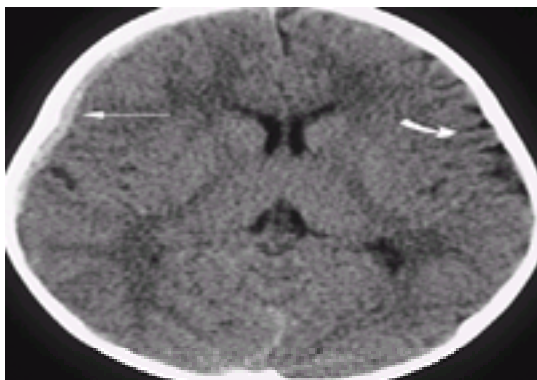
Brain swelling. This 1-year-old boy fell from a second-story window. The neurologic examination was normal. A head computed tomography (CT) scan shows a small, right-sided subdural hematoma in the temporal region. Note also the effacement of the sulci on the right (*straight arrow*), which can be compared with the normal sulci on the left (*curved arrow*). There is also a mild shift of the midline toward the left.
